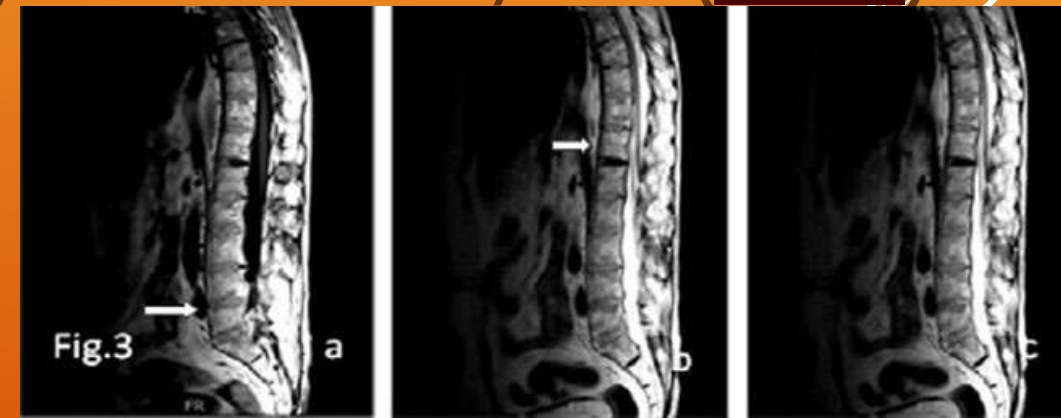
Ankylosing Spondylitis. (a) T1-weighted sagittal image. (b) T2-weighted sagittal image. (c) T1-weighted post contrast sagittal image. There is squaring of vertebral bodies with loss of intervertebral disc spaces in the dorso-lumbar spine. There is also a prominence of the prominent anterior longitudinal ligament.
